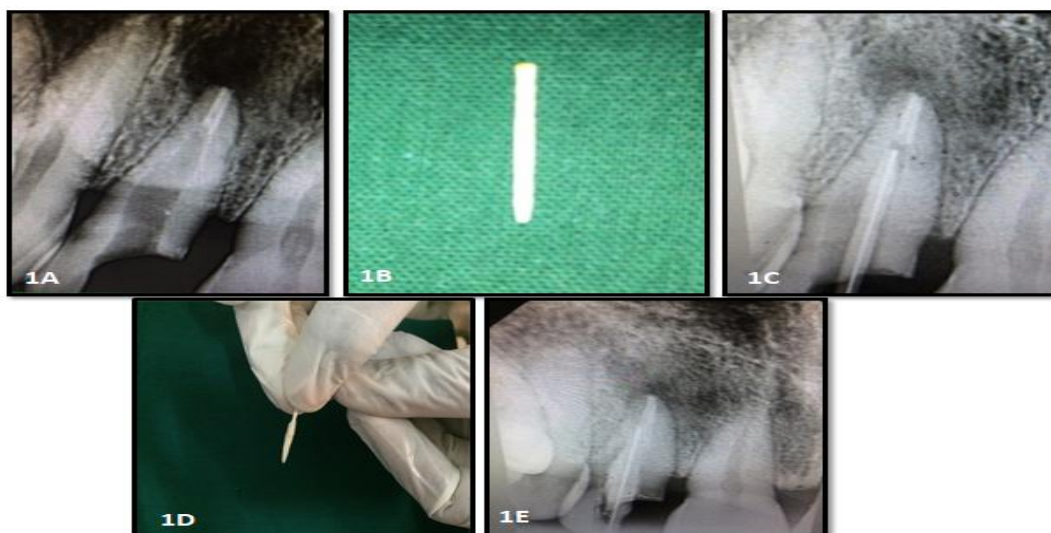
Iatrogenically enlarged root canal space (1A), Glass fiber post size- 2 (1B), Glass fiber post size- 2 was checked for the fit (1C), Anatomically customized fiber post (1D), Post- operative radiograph after luting anatomically customized fiber post (1E)
